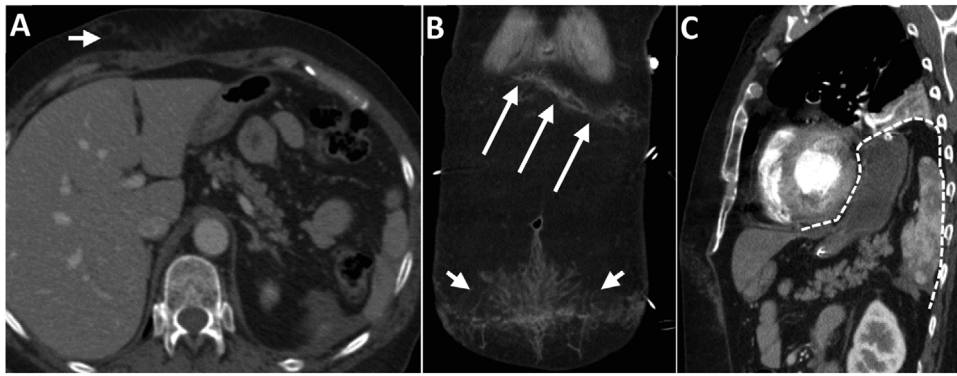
65-year-old woman, front passenger in a road traffic accident, with seatbelt syndrome. A) Axial CT image (mediastinal window) showing fat stranding in the subcutaneous tissues of the chest wall (arrows). B) Coronal reconstruction of CT in which the angle of the subcutaneous fat stranding is better appreciated (oblique in the lower thoracic wall [long arrows] and horizontal in the abdominal wall [short arrows]). C) Sagittal reconstruction of CT scan showing a rupture of the left hemidiaphragm with herniation of the stomach, pancreas and spleen (dashed line).
